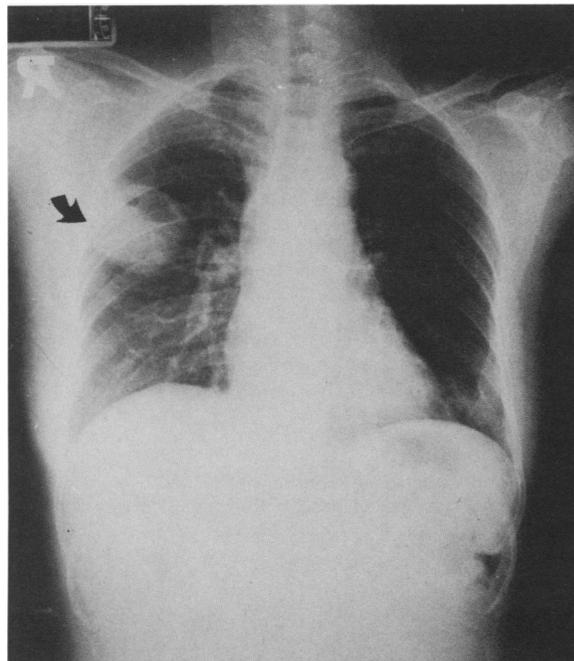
Chest X-ray performed 1 week after positive blood culture revealed a cavity (pointed by the arrow) in the posterior segment of the right upper lung with an air-fluid level.
